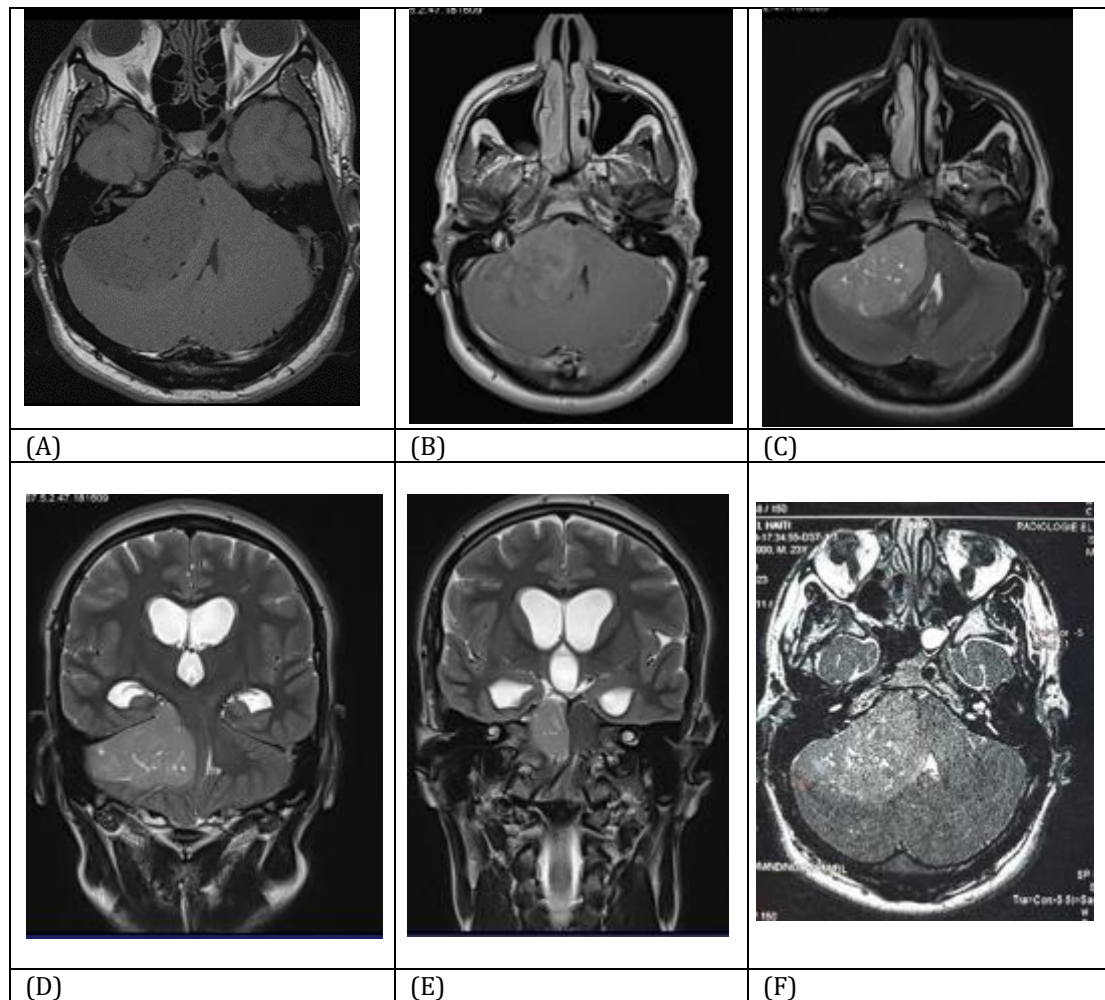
The preoperative MRI images show : An isosignal on T2 and FLAIR images (C, D, E,F), hyposignal on T1 image (A), and mild enhancement after Gadolinium injection (B)
